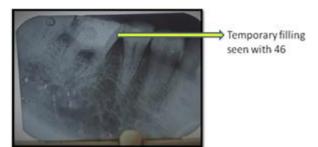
Pre operative IOPA X-ray with 46
